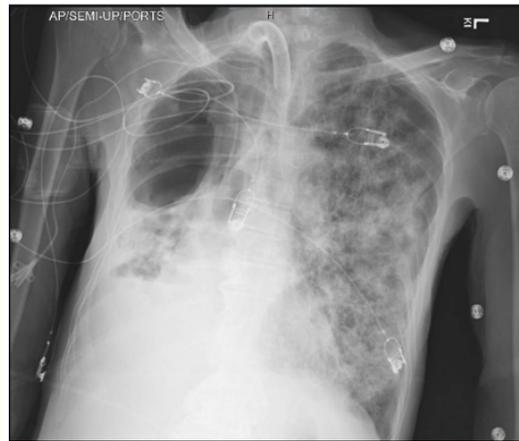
Antero-posterior chest x-ray of the same patient after 2 months. Large cavity still present and patient developed acute respiratory distress syndrome. Endotracheal tube can be observed with the tip about 3 cm above carina.
